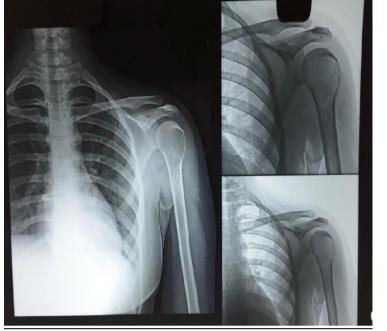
XRAY left humerus shows illdefined expansile eccentric lesion with wide margins and cortical breach is seen in proximal diametaphyseal region of left humerus. Adjacent soft tissue swelling with displacement of fat planes is also seen.
